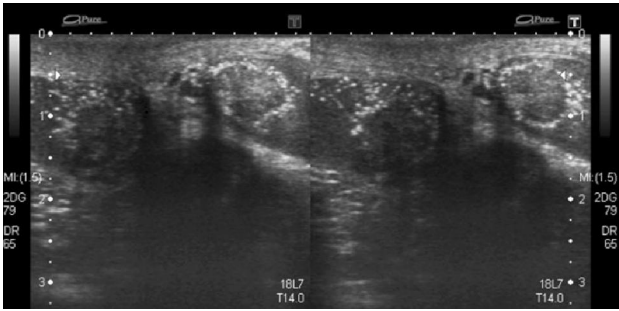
Sonographic images showing multiple hypoechoic rounded masses with peripheral hyperechoic rim in the testes of a patient with congenital adrenal hyperplasia. These were suggestive of adrenal rest tumors.
